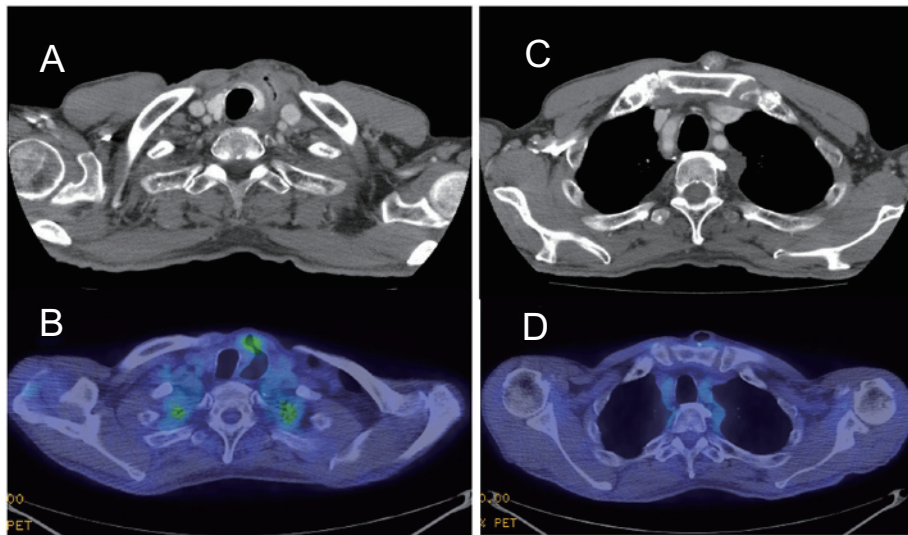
CT and FDG-PET/CT image after chemoradiation with hyperthermia (May, 2007).
